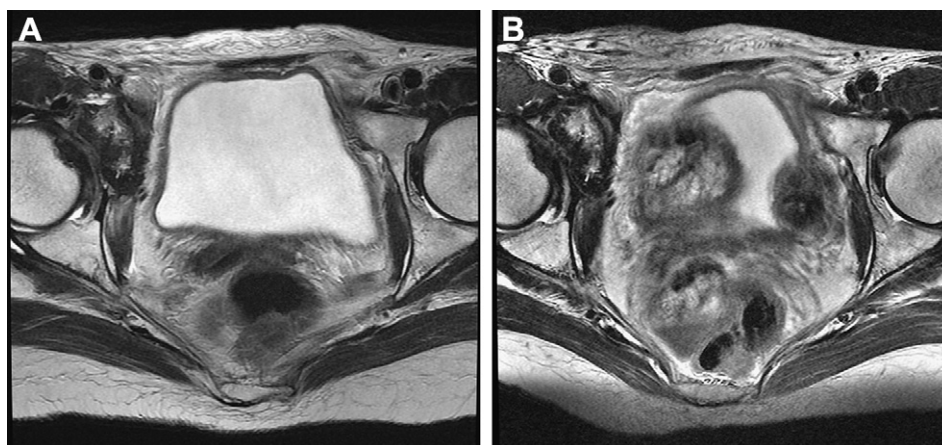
Magnetic resonance imaging follow-up on (A) July 7, 2010; and (B) January 23, 2011.
